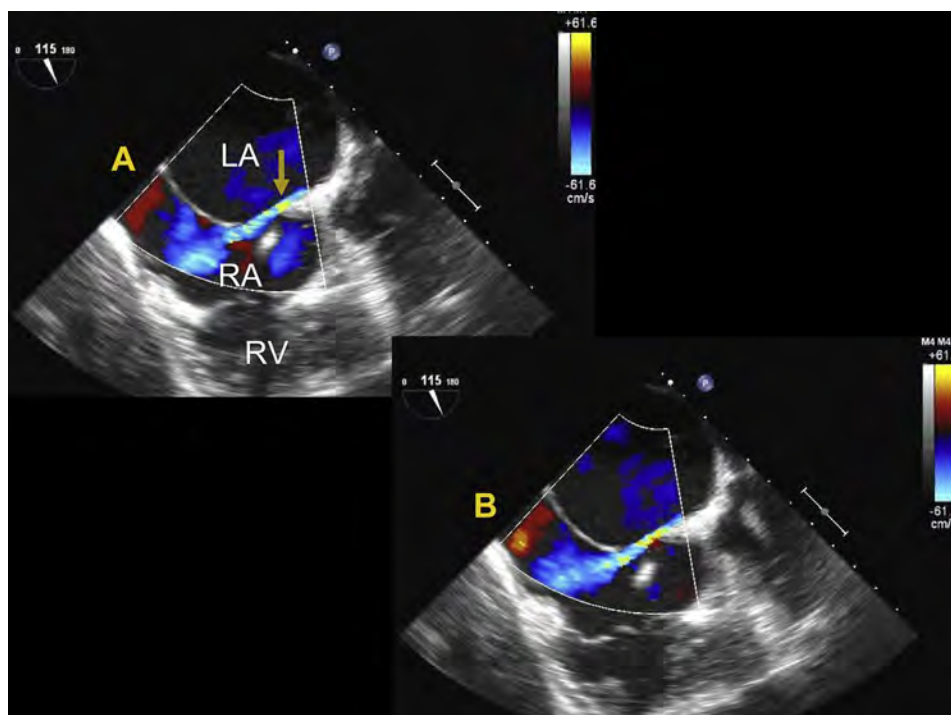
Two-dimensional TEE of a “stretched” PFO (yellow arrow) in bicaval views (A and B) with color Doppler flow from left to right in an adult patient. See also [Video 1](#).
